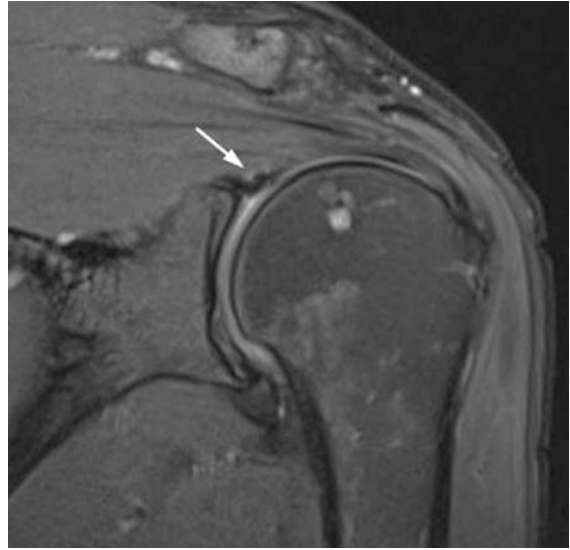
SLAP II lesion. (a) Coronal fat-suppressed T2-weighted MR arthrographic image demonstrates detachment of the superior labrum and biceps anchor from the underlying glenoid with slightly irregular margins (arrow), consistent with a SLAP II lesion. (b) Axial
